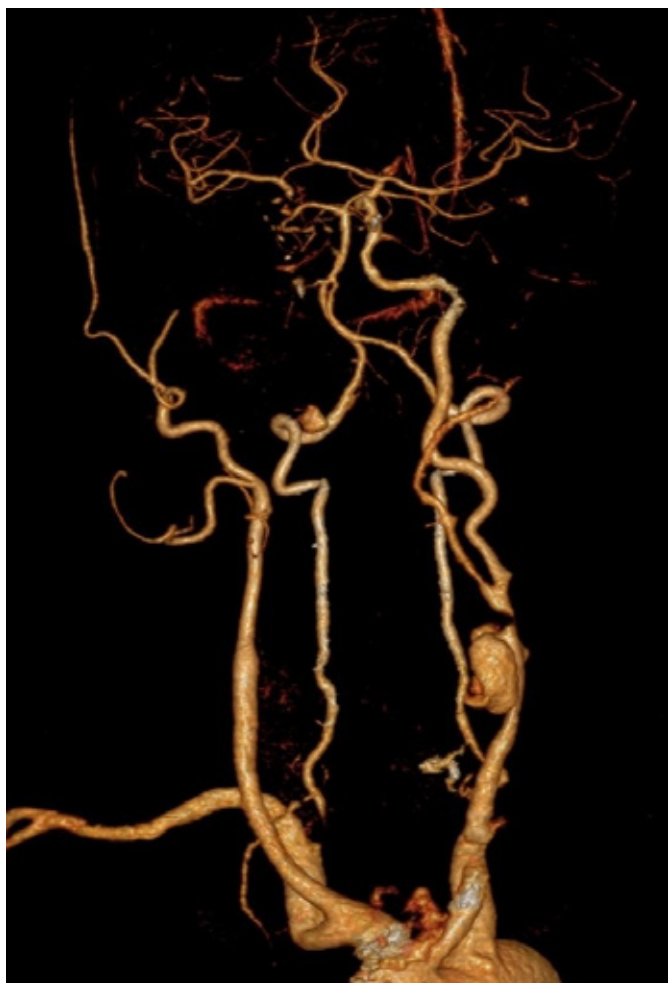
3D reconstruction of computed tomography angiography. The aneurysm is arising from CCA. Also note the near occlusion stenosis at the carotid bifurcation.
